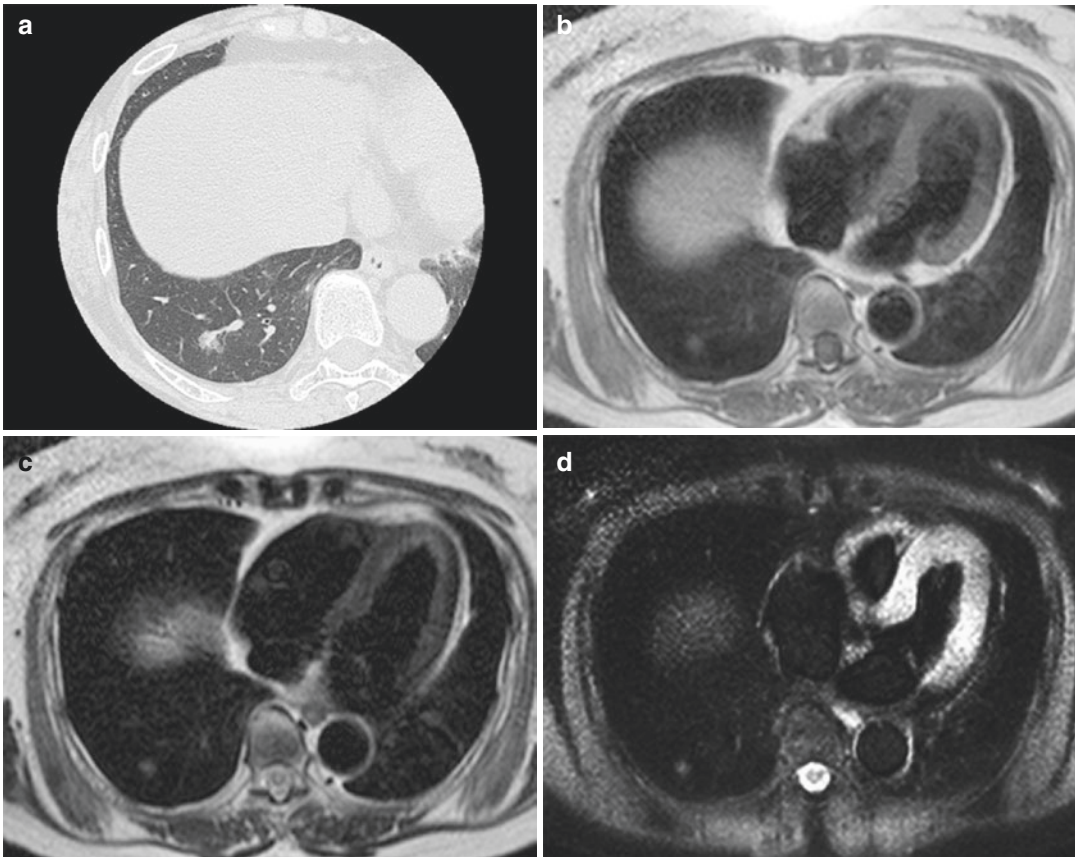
A 71-year-old female with adenomatous hyperplasia in the right lower lobe. Thin-section CT indicates ground-glass attenuation in the right lower lobe (a). Black-blood T1-weighted turbo SE (b), T2-weighted
